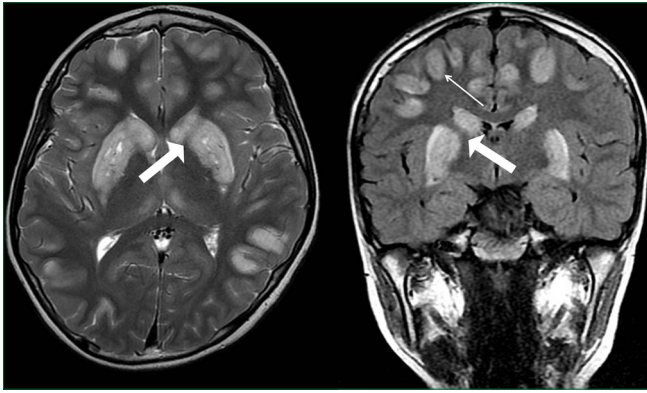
T2 MRI images show; (big arrows) bilateral symmetrical high signal changes in Caudate nuclei and Putamen, with high signal changes in the deep cortical gray matter (small arrow), all changes that indicate academic encephalopathy
